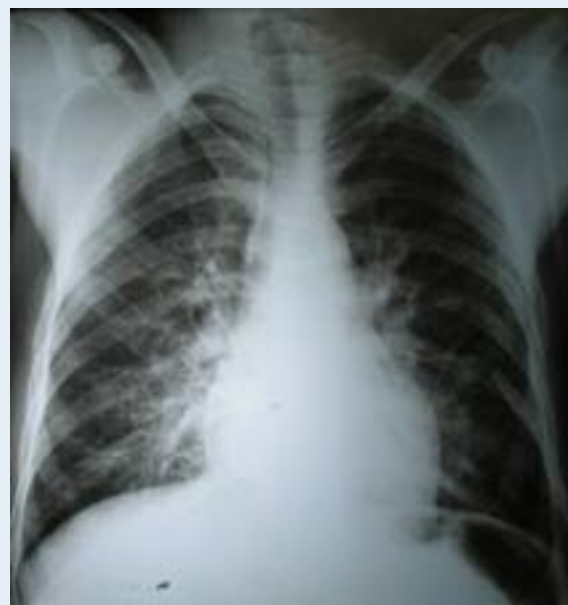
Chest radiography revealed pulmonary congestion and multiple fractures in bilateral ribs.
